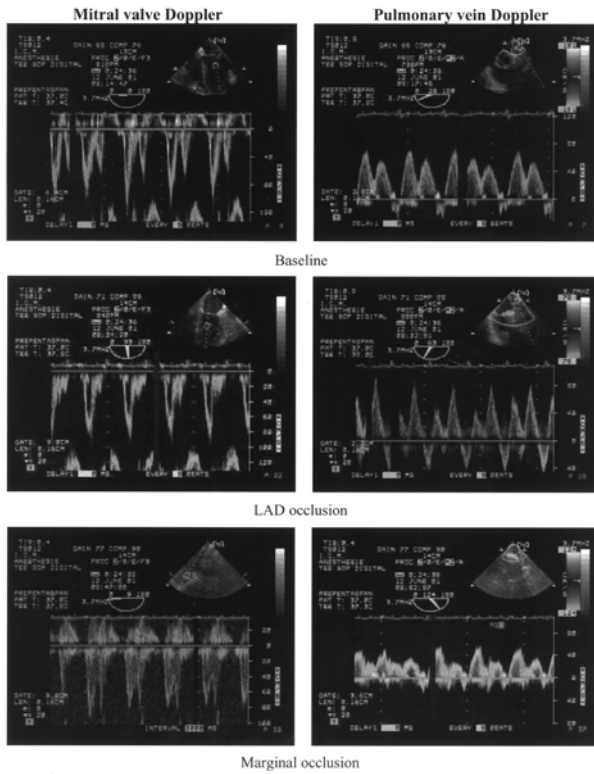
Mitral valve and pulmonary vein Doppler inflow during baseline, following left anterior descending (LAD) and marginal artery occlusion. During LAD occlusion, a restrictive pattern appears with a predominant E wave and a reduced S to D wave on the pulmonary vein Doppler signal. The application of the stabilizer probably caused a restrictive pattern because of the compression of the LV. This pattern was rather a relaxation abnormality during marginal occlusion, sometimes observed during myocardial ischemia.
